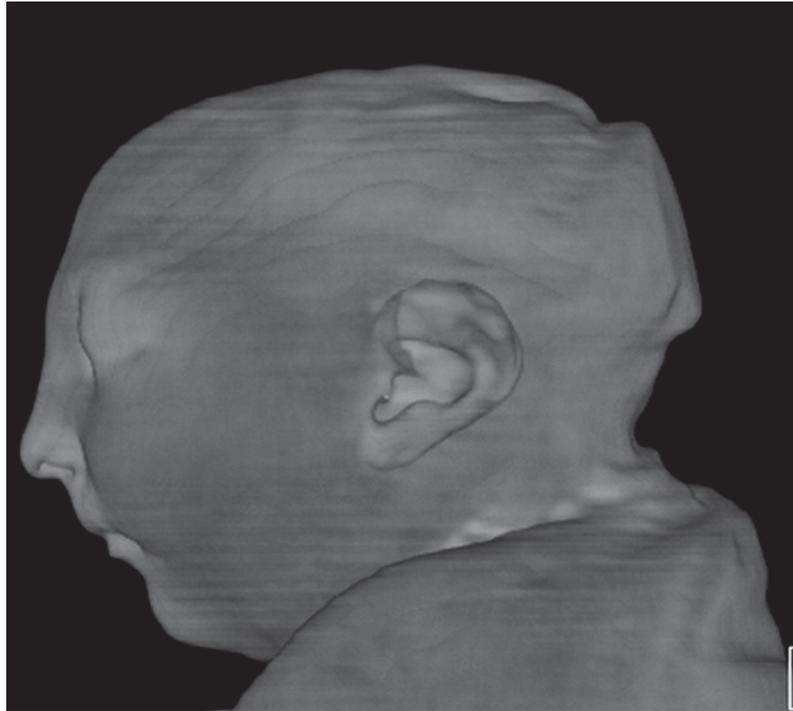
Images in the case of a 24-year-old woman pregnant with twins, with characteristic rash at 9 weeks of pregnancy and confirmed Zika virus infection. (For each pair of images, the first image is of twin A, and the second image is of twin B.) At 14 weeks of gestational age, the fetal head size of both twins was normal. The head size never went below the 3rd percentile for either fetus in examinations at 19–28 weeks. (a, b) Sagittal and (c, d) axial fetal MR images were obtained at 36 weeks. (e, f) Axial and (g, h) surface reconstruction postnatal CT images and (i, j) axial T2-weighted and (k, l) coronal MR images were obtained 1 week after delivery at 38 weeks of gestational age. There is severe microcephaly with profound frontal lobe hypoplasia. Calcifications in the subcortical white matter at the gray matter–white matter junction are visualized. Both twins have a flattened appearance of the pons. The spinal cord is atrophic (best seen on a). Redundant skin is seen in the occipital region. There is polymicrogyria involving the frontal and parietal regions and atrophic cortex and white matter in the occipital regions. Each twin has hypoplasia of the corpus callosum, with prominent fornices. There is abnormal myelination in the occipital region that, in twin A (i), has the appearance of a cyst or septation within the ventricle. The cerebellum is somewhat small and nodular. There is lack of rotation of the hippocampi.
